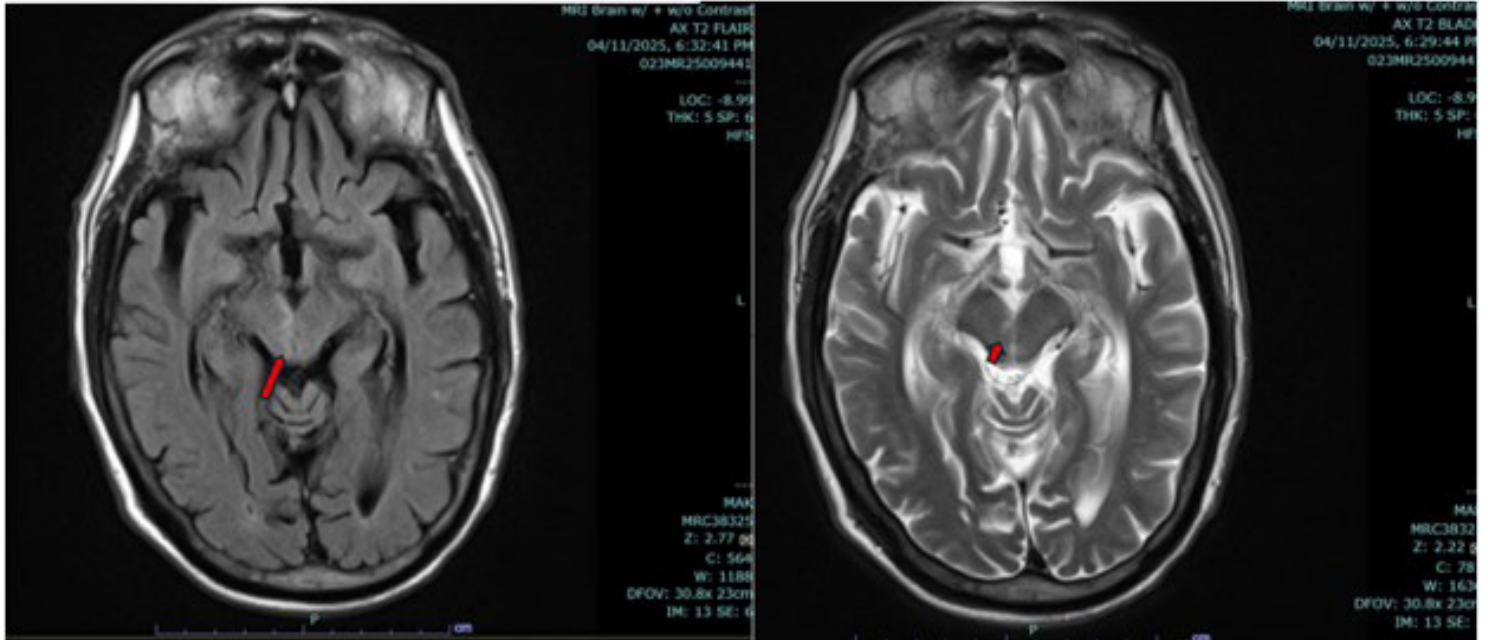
A small focus of T2/FLAIR hyperintensity in the right medial midbrain in the territory near the cerebral peduncle indicated with the red arrows consistent with a lesion relevant to Nothnagel syndrome.
